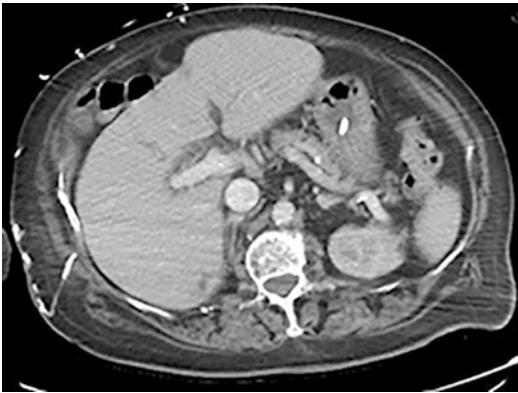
Computed tomography demonstrating choledocholithiasis
